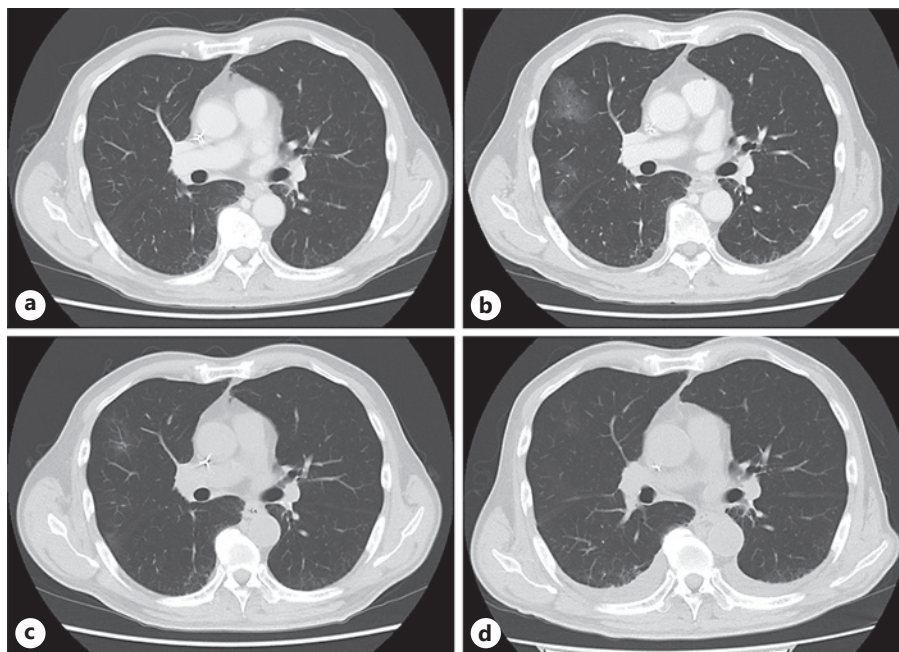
CT findings of interstitial pneumonitis. a CT scans prior to the intake of dietary supplementation with *Agaricus blazei* Murill showed no evidence of interstitial pneumonitis. b CT scans revealed a nonspecific interstitial pneumonitis in the right upper lobe of the lung. c, d CT scans after 2 and 6 weeks of *Agaricus blazei* Murill withdrawal showed that the nonspecific interstitial pneumonitis has improved. CT, computed tomography.
